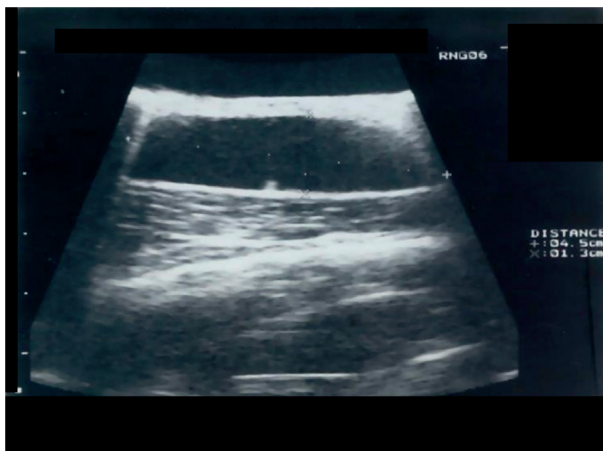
Ultrasound of the right breast region: presence of an oval anechoic formation measuring approximately 50 x 13 mm of the cystic type with hyperechoic sedimentation which departs from the posterior wall, with fairly defined contours.
